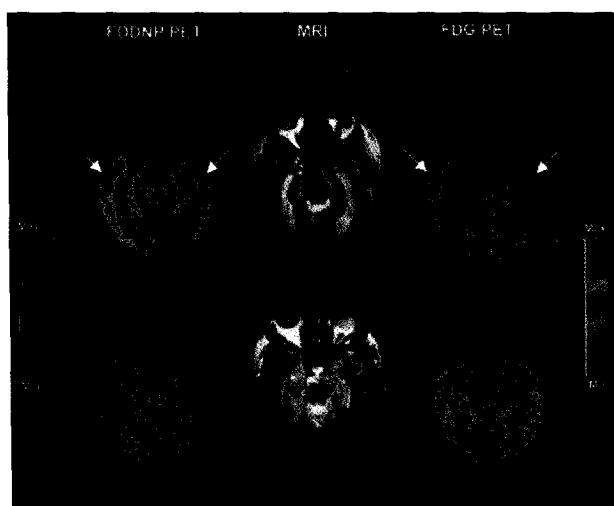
Multimodality in vivo imaging of an AD patient and a control. The ¹⁸F FDDNP and PDG images of each stage are coregistered to their MRI images. Areas of FDG hypometabolism are matched with the localization of neurofibrillary tangles and senile plaques resulting from ¹⁸F FDDNP binding(marked arrows). The same brain regions exhibited atrophy(as shown with MRI) in the AD patient. The colorbar represents the scaling of the ¹⁸F FDDNP and FDG images.(From ref. 33.)
